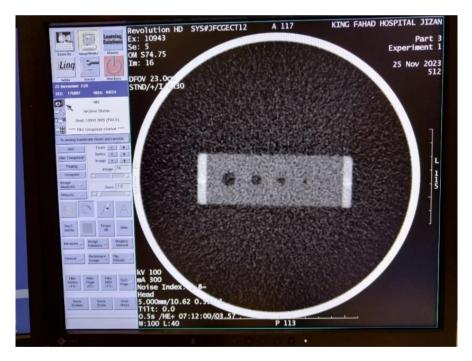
The CT image of the Second section with the middle parameters of the experiment.
